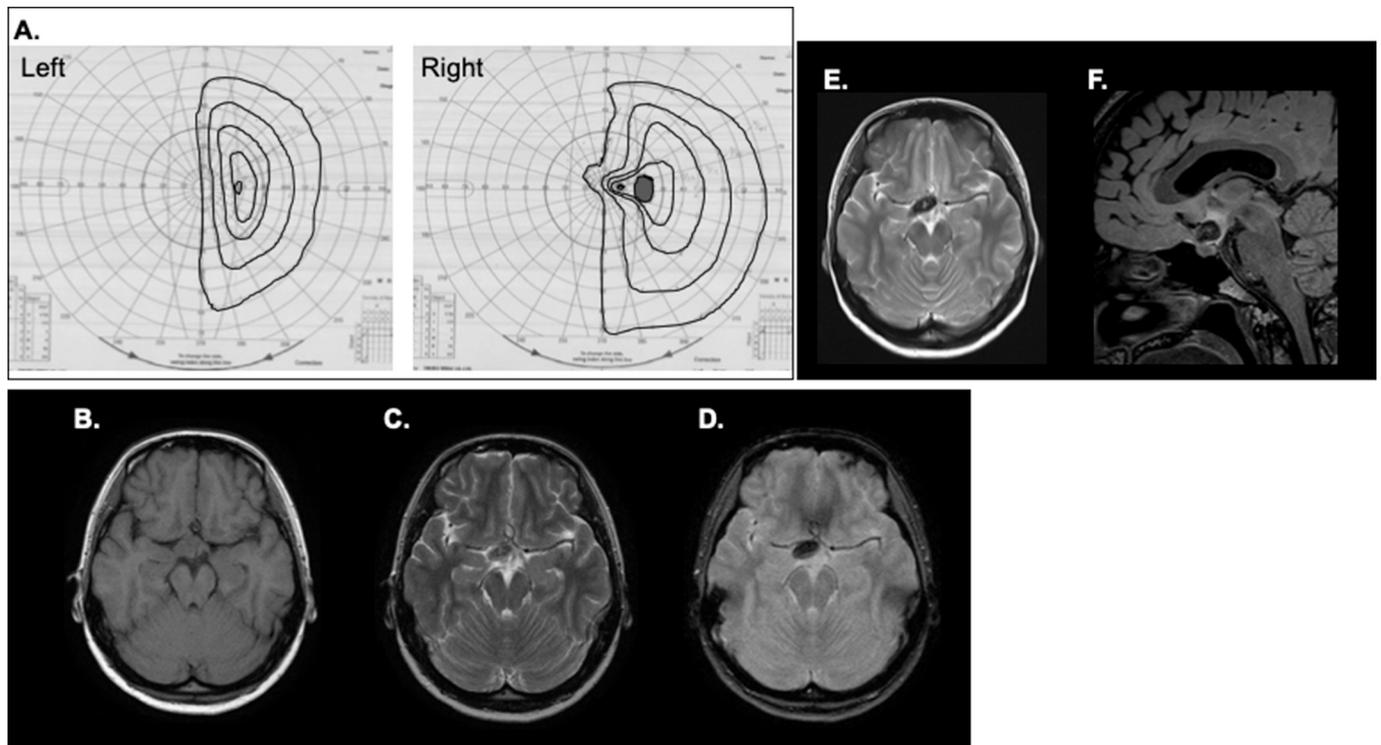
Examinations before cesarean section. A: Goldmann's perimetry test performed at a primary care ophthalmologist showing left homonymous hemianopia. T1-weighted imaging (B), T2-weighted imaging (C), and Gradient-echo T2-weighted imaging (D) showing the center of the mass as hypointense on admission. E: T2-weighted image on hospital day 4 showing the hematoma enlargement compared with initial images. F: Sagittal image of fluid attenuated inversion recovery on hospital day 4 showing hyperintensity area extending to the hypothalamus and pituitary stalk.
